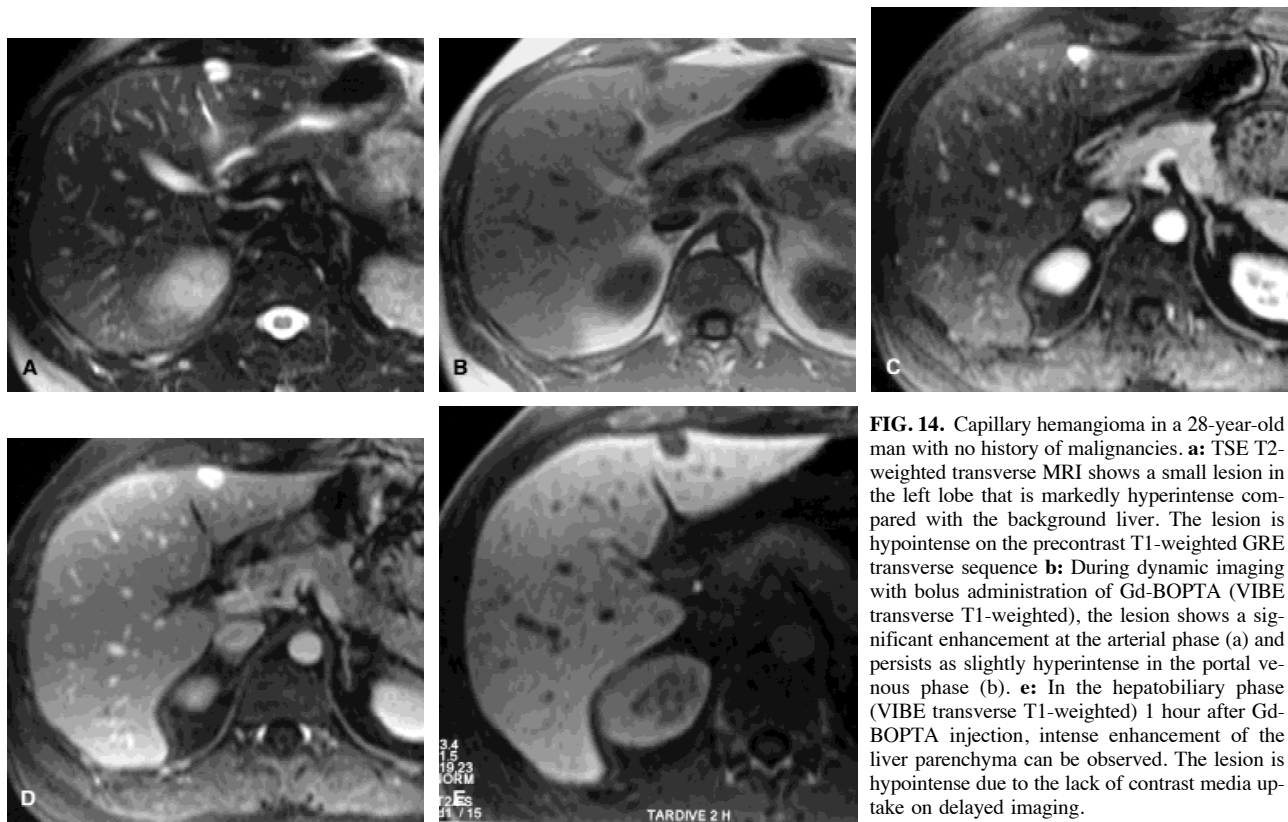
Capillary hemangioma in a 28-year-old man with no history of malignancies. a: TSE T2-weighted transverse MRI shows a small lesion in the left lobe that is markedly hyperintense compared with the background liver. The lesion is hypointense on the precontrast T1-weighted GRE transverse sequence b: During dynamic imaging with bolus administration of Gd-BOPTA (VIBE transverse T1-weighted), the lesion shows a significant enhancement at the arterial phase (a) and persists as slightly hyperintense in the portal venous phase (b). e: In the hepatobiliary phase (VIBE transverse T1-weighted) 1 hour after Gd-BOPTA injection, intense enhancement of the liver parenchyma can be observed. The lesion is hypointense due to the lack of contrast media uptake on delayed imaging.
